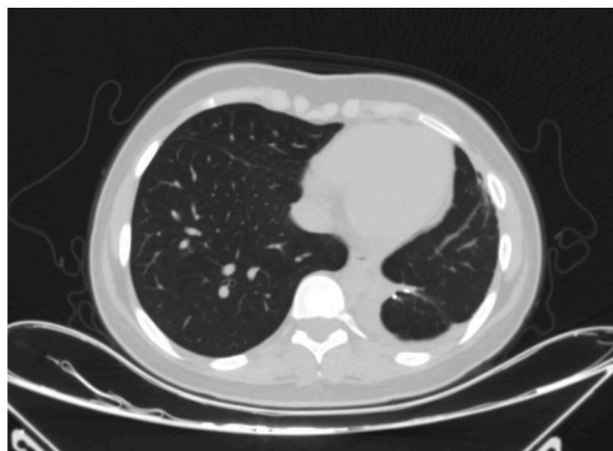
Chest CT imaging of patient after surgery
